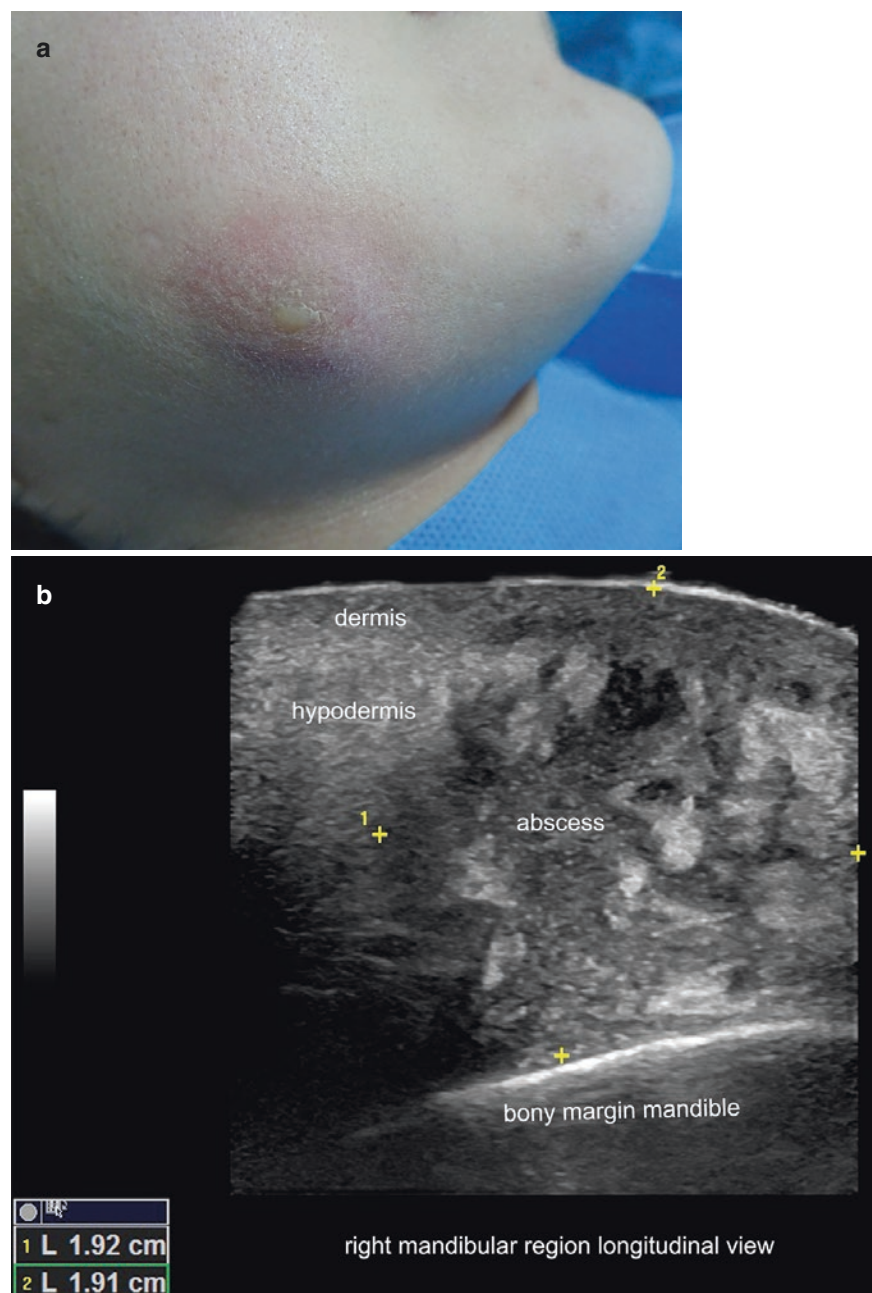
Abscess. (a) Clinical image of the right mandibular region. (b, c) Ultrasound (b, greyscale and c, color Doppler; longitudinal views, right mandibular region) shows a hypoechoic hypodermal fluid collection with irregular borders and inner echoes. There is increased echogenicity of the surrounding hypodermis, as well as thickening and decreased echogenicity of the dermis. Notice the slight acoustic reinforcement artifact beneath the collection. On color Doppler, there is dermal and hypodermal increased vascularity in the periphery of the abscess. See Video 9.1.
